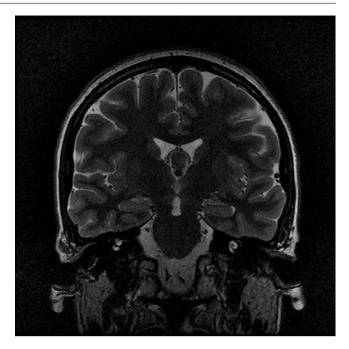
T2-weighted coronal MRI shows a colloid cyst of the third ventricle in a patient with small ventricles. Although technically challenging, these lesions can be safely resected through a purely endoscopic approach
